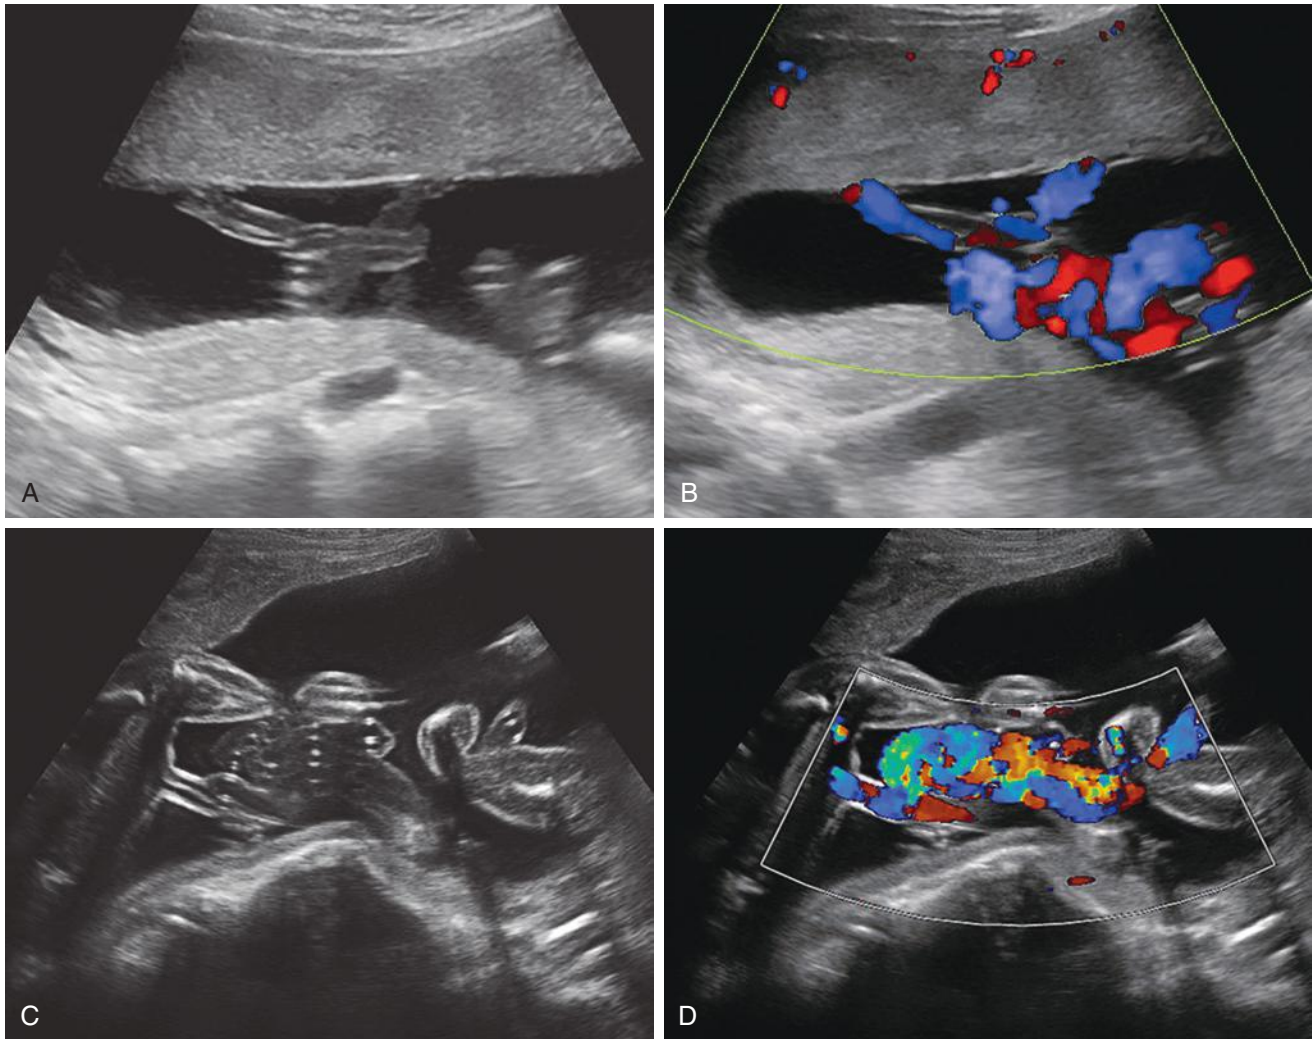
Cord entanglement. A, In this monozygotic twin gestation at 20 weeks, there is cord entanglement near the level of the placental cord insertion sites—which are in close proximity to one another. B, Color Doppler sonography may help facilitate visualization of cord entanglement. C, Cord entanglement is also apparent near the insertion of the umbilical cord at the fetal ventral abdominal wall. D, Again, color Doppler sonography demonstrates the two entwined cords. The infants were delivered by cesarean at 32 weeks, without incident.
